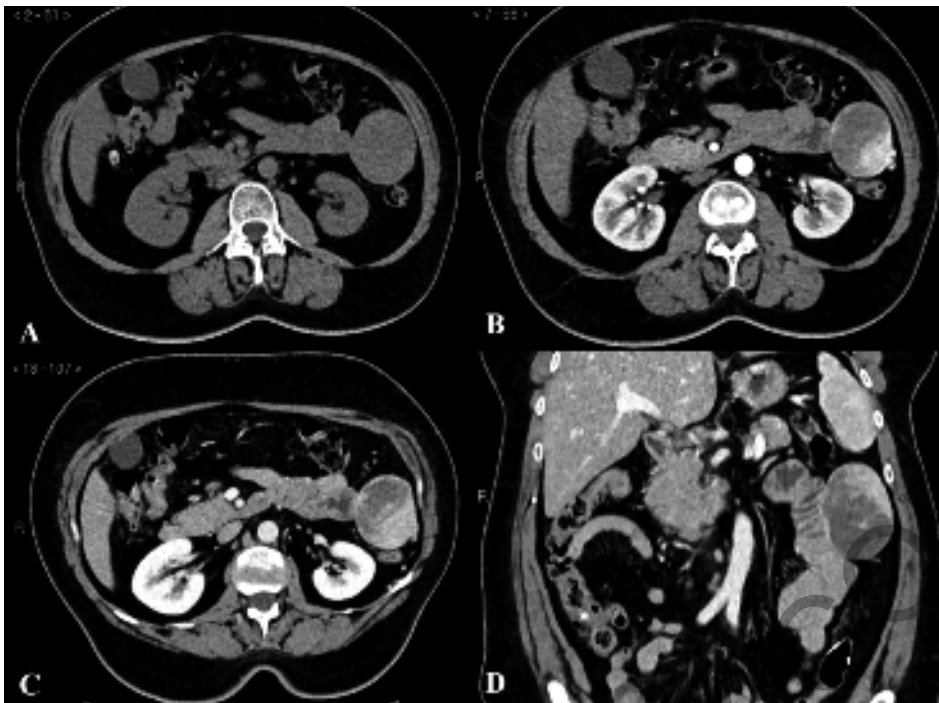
Intravenous contrast-enhanced CT revealed a rounded, lobulated mass, measuring 6x5.8x8cm (APxLLxCC), adherent to the wall of the first jejunal loop, hypodense on basal acquisition (A) and, on contrast enhanced acquisition, showing peripheral enhancement with central hypovascularity (B, arterial phase. C, portal phase. D, coronal plain).
